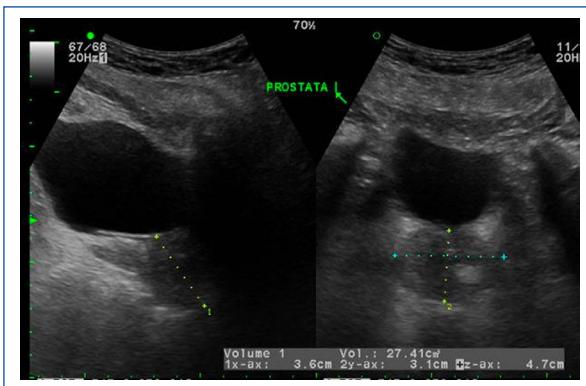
Prostate ultrasound, prostate volume 32 cm³.
